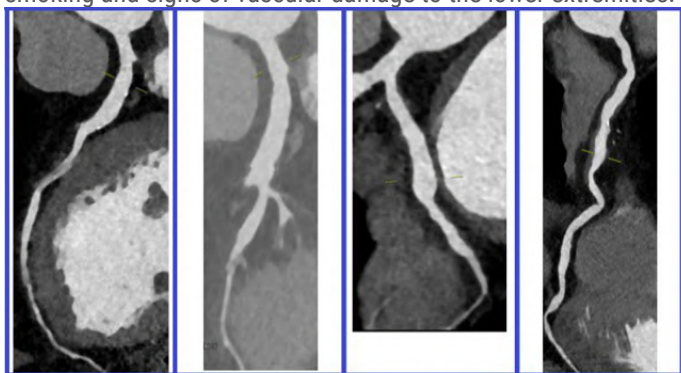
CT angiography of coronary arteries in a 47-year-old man with thromboangiitis obliterans
